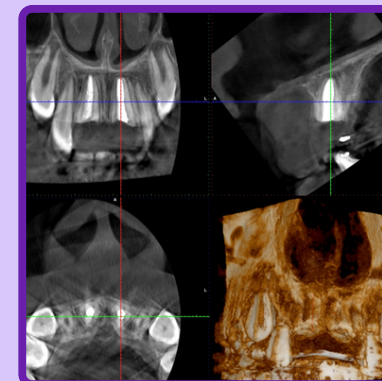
Recall ConeBeam CT
